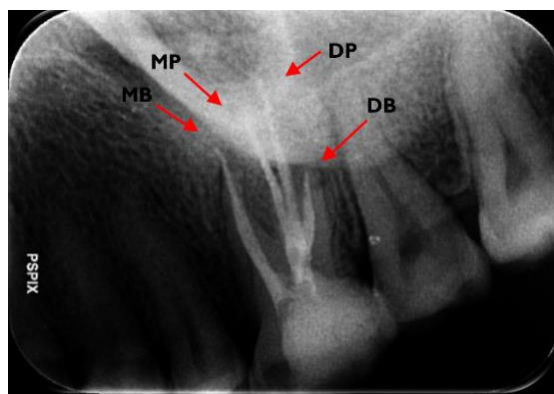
Master cone radiograph shows mesiobuccal (MB) distobuccal (DB), mesiopalatal (MP) and distopalatal (DP) canals
